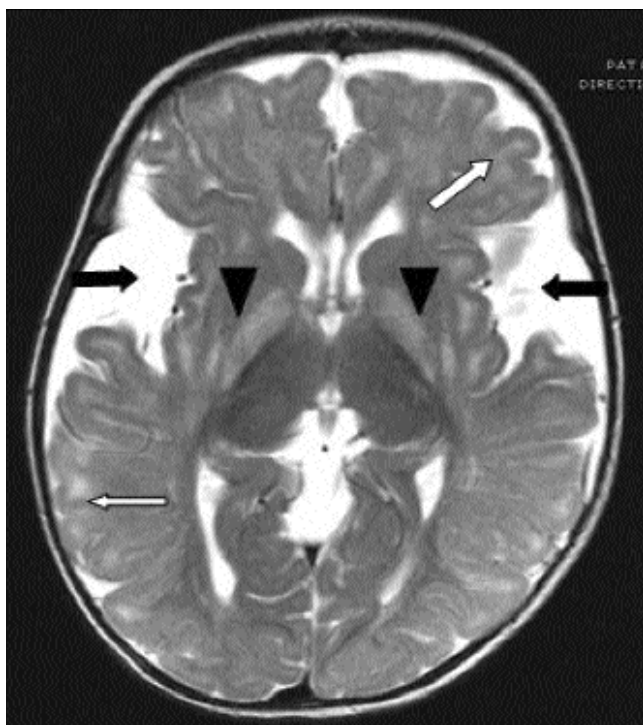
MRI brain T2-weighted image of patient 1. Black arrows showing open sylvian fissure secondary to fronto-temporal atrophy, black arrow heads showing hyperintense signals in globus pallidus, white arrows showing delayed myelination.
